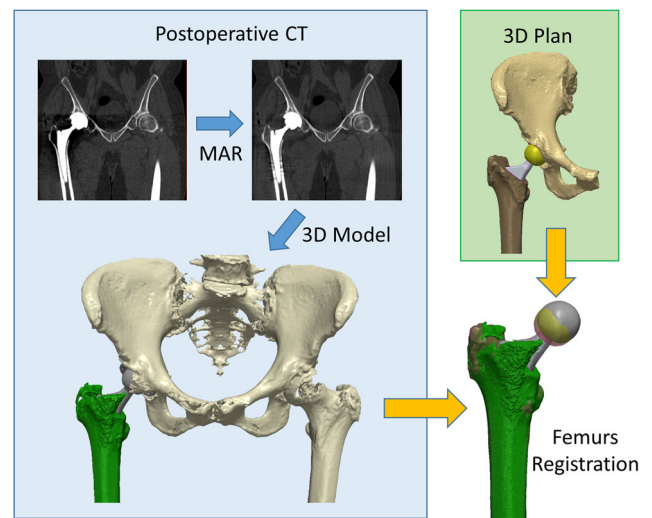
Processing chain to align the postoperative CT and the 3D plan. The CT is first processed with a Metal Artifact Reduction (MAR) algorithm, then 3D models of the bone and the implant are generated and finally, the femur is labeled. The femur and the femoral components of the plan are registered to the postoperative model of the femur. In the bottom right image, the achieved and plan femoral components are overlaid after the femur registration. 3D, three-dimensional; CT, computerized tomography [Color figure can be viewed at wileyonlinelibrary.com]
